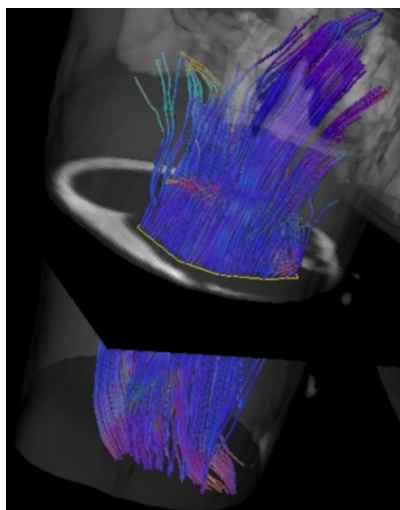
Visualisation of the diffusion tensor MRI derived muscle fibre trajectories.
